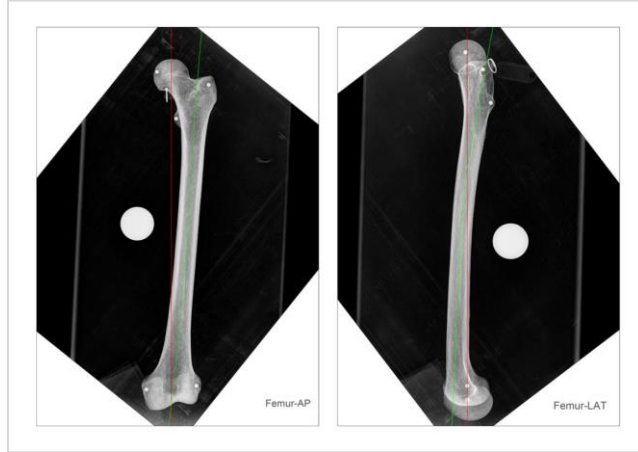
X-ray images of a femur bone in Anterior-Posterior (AP) and Lateral (LAT) views
